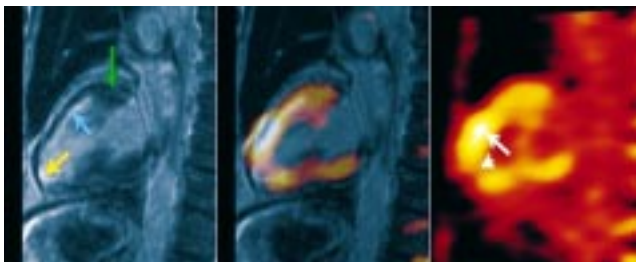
On the other hand when fusing the FDG-PET functional image (right) with the inversion recovery post contrast MRI anatomical image (left), the fused image (middle) could be easily assessed. Note that more details are visible from MRI that correspond excellently to the perfusion/metabolic images in Figure 2A: no or minimal contrast enhancement in the basal part of the anterior wall (green arrow) is typical of a viable myocardium; the clear rim of contrast enhancement in the apical 2/3 of the anterior wall represents a subendocardial scar (blue arrow), while the subepicardial myocardium is still viable and hibernating (white arrow); transmural deposits of the contrast medium in the apex (yellow arrow) represent nonviable myocardium (white arrowhead).
